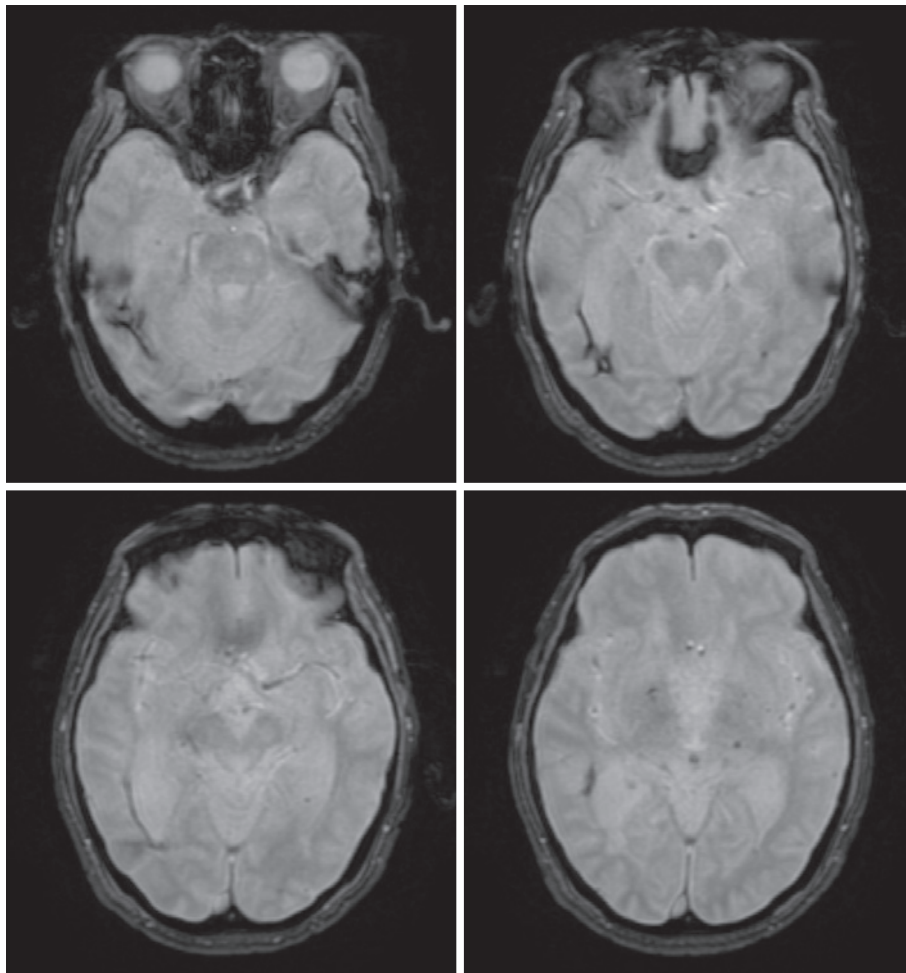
MRI T2*WI images showing the subcortical hemorrhage in the right temporal lobe.
